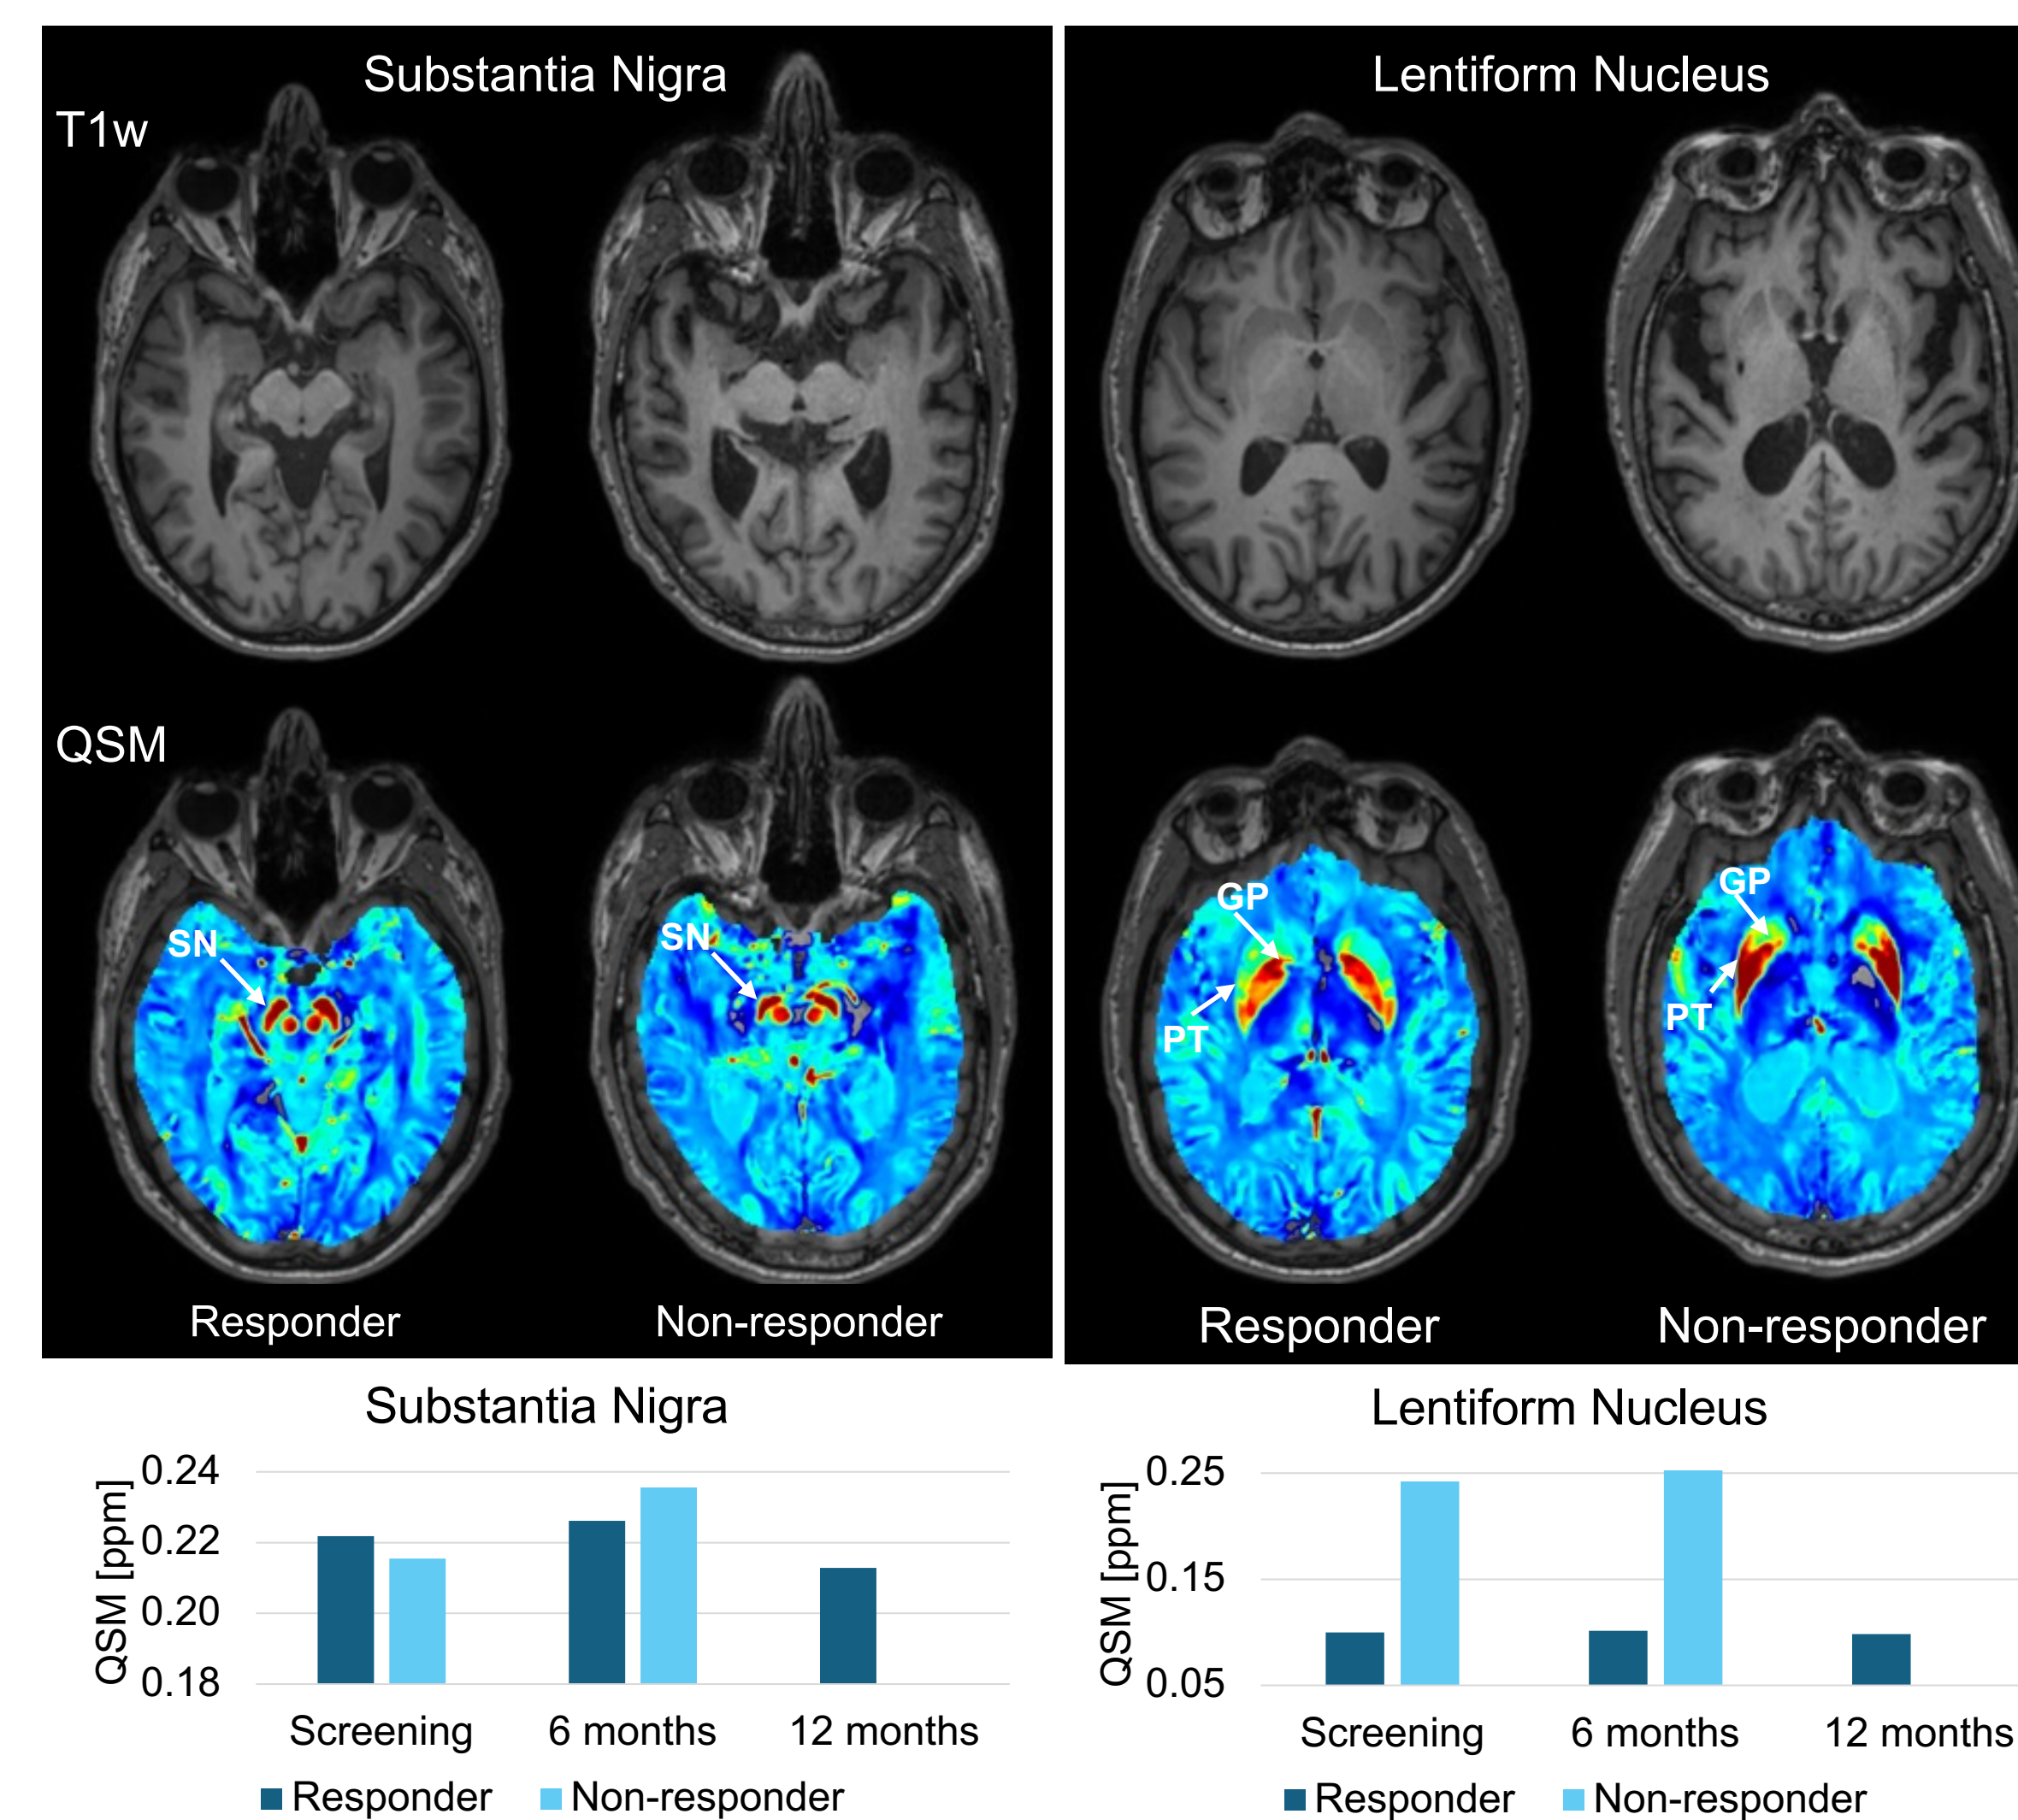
T1-weighted and QSM images from a responder (62-year-old male) and a non-responder (65-year-old male), displayed at the levels of the substantia nigra (SN, left) and lentiform nucleus (putamen (PT) and globus pallidus (GP), right). Corresponding bar plots present QSM values for the SN and lentiform nucleus in the responder (dark blue) and non-responder (light blue) at screening, 6 months, and 12 months. The responder shows stable or decreasing QSM values, while the non-responder exhibits an increase over time.
